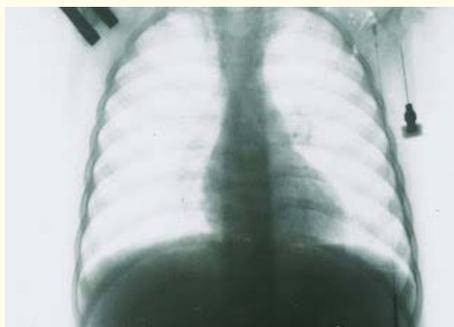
X-ray photograph of the same patient (see Figure 5) five days following the clinical treatment (vagosympathetic blockades, antibiotic therapy, bronchus-draining therapy, including lavages through micro-tracheostoma). Full recovery of airiness in both lungs.
